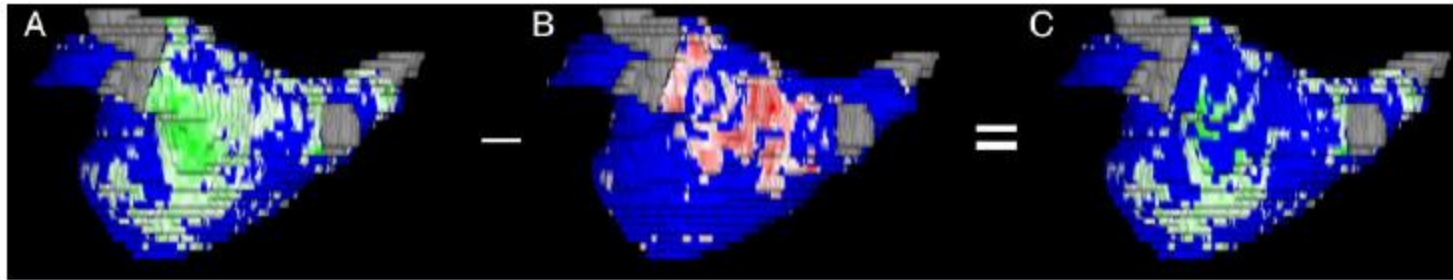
Calculation process of residual fibrosis. The pre-ablation delayed enhancement-magnetic resonance imaging scan (A) is reduced by the post-ablation delayed enhancement-magnetic resonance imaging scan (B), resulting in the residual fibrosis shell (C).
